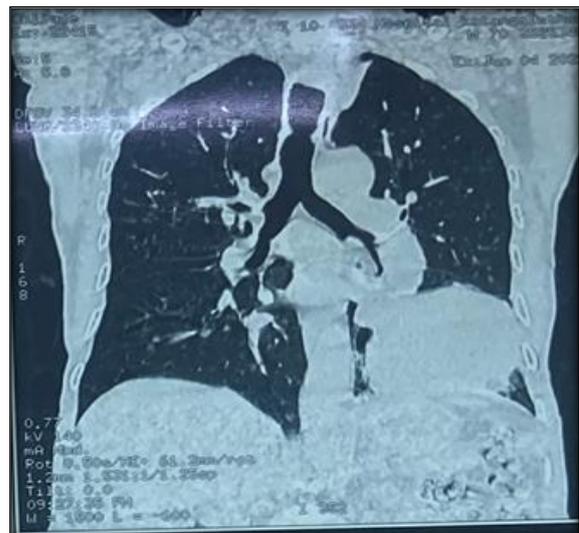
CT Chest showing endobronchial mass
